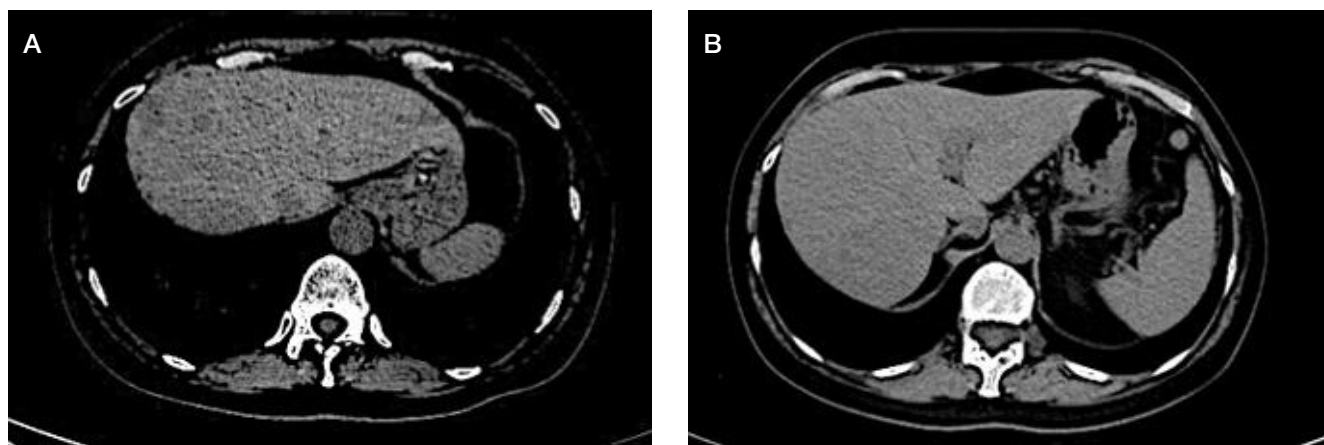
A, B. Abdominal CT, 22.12.2021. multiple metastatic foci (size up to 2.6 cm) in both lobes
